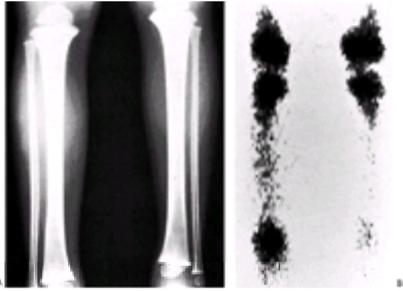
A: A seven-year-old girl complained of pain in her leg for about 24 hours. Examination revealed diffused swelling in the leg and a rapidly spreading erythema. Radiographs show superficial soft tissue swelling on the right leg, but the deep soft tissue layers are not swollen. This appearance indicates cellulitis. B: Bone scan was obtained on this patient and mistakenly interpreted as showing osteomyelitis. The diffused pattern of uptake is not typical of osteomyelitis, but represents the effects of increased circulation throughout the bone, secondary to inflammation and acute disuse.
